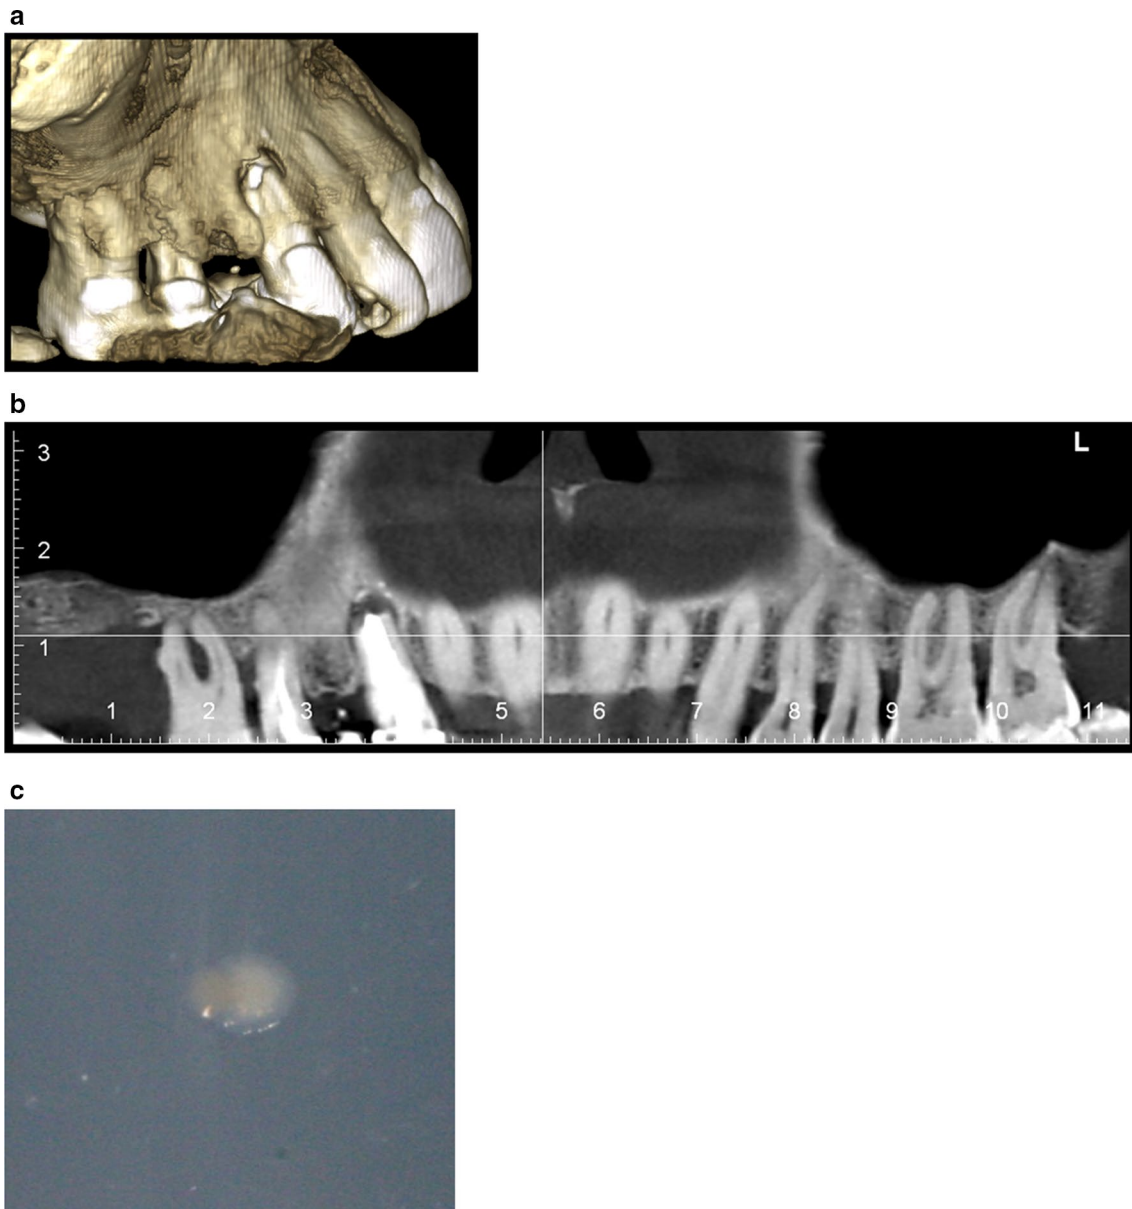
Severe periodontitis: Corn-beam aspect (a) and radiographic aspect (b) of a patient who yielded mixed anaerobe infection (c white colony, "*M. massiliense*"; pink colony, *P. piscicolens*)
